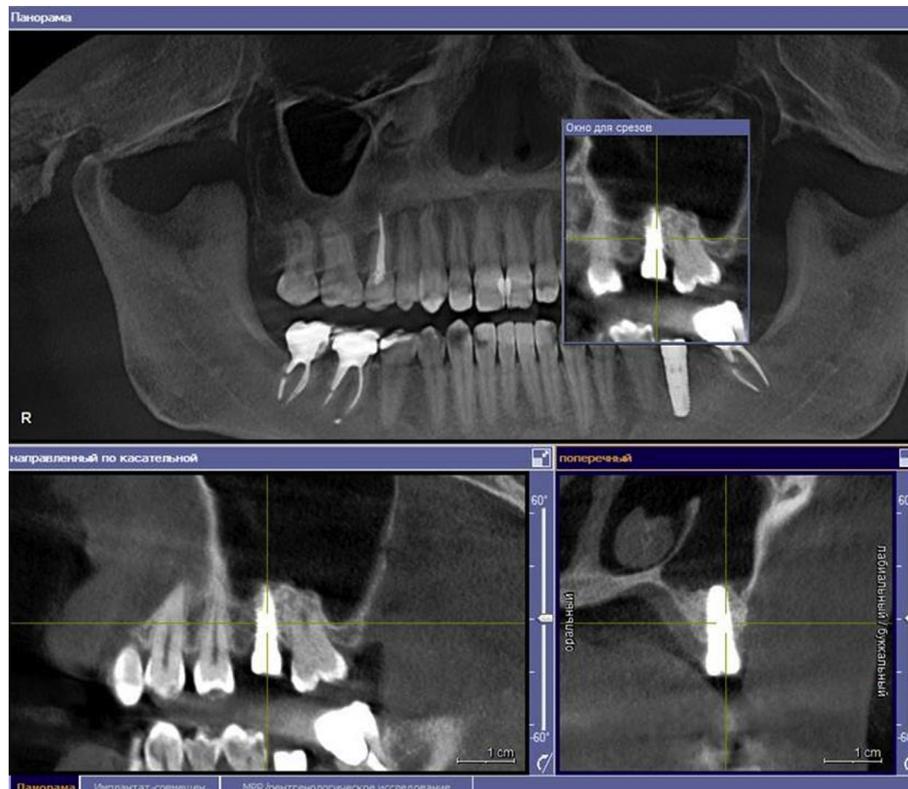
Postoperative CT scan of a patient with foreign body of the maxillary sinus (filling material) with polyposive sinusitis following simultaneous endonasal sanitation of the maxillary sinus, sinus-lifting, and dental implantation.
